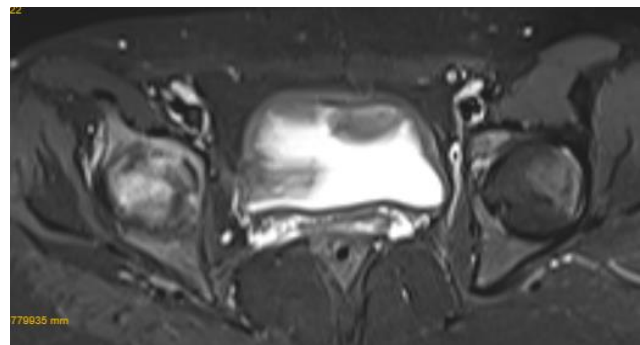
Axial section of the MRI showing thinning of the articular cartilage covering the medial third of the right femoral head.
